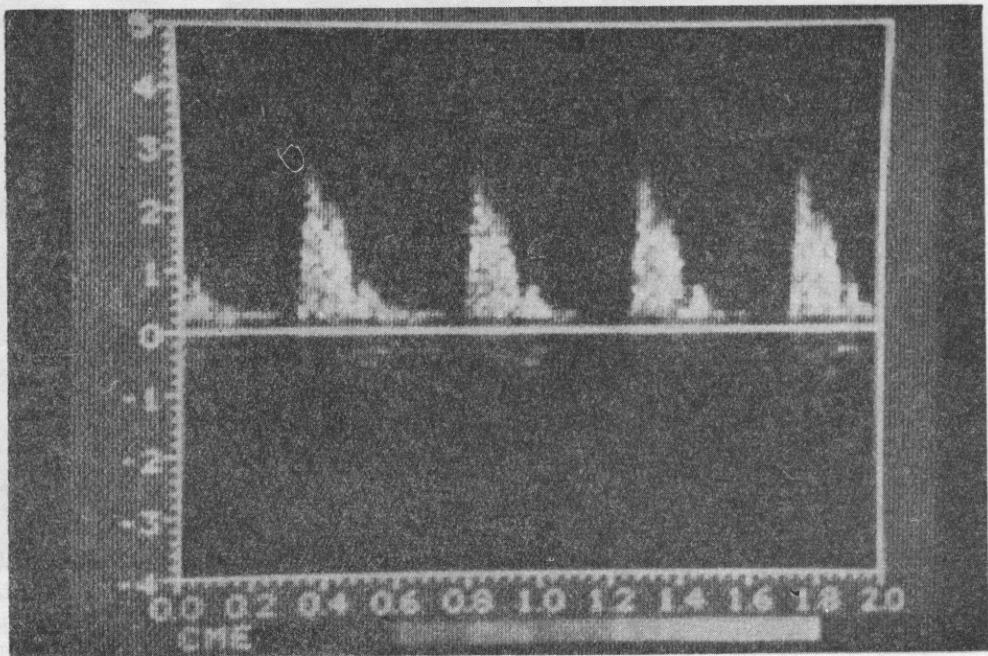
FSA of Doppler signals in the normal external carotid artery. The probe beam angle is approximately  $45^\circ$  with the vessel as in Fig. 1. The frequency energies are rather evenly distributed across the spectrum indicating a more parabolic flow profile. The waveform is typical of the external carotid with lower diastolic velocities represented
